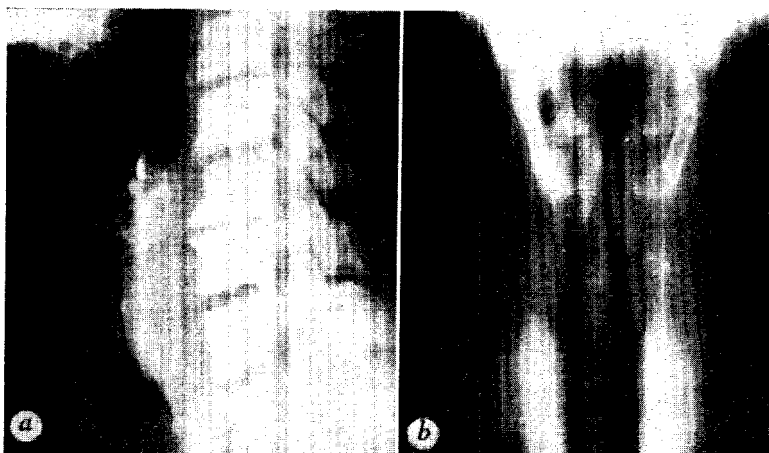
a*, Lateral roentgenogram of the larynx in case 15, demonstrating a retrotracheal soft-tissue mass causing significant narrowing of the airway: note the areas of calcification; *b*, tomogram of the larynx in the same case as in *a*, demonstrating some thickening of the true cords, and a tumor mass in the subglottic region on both sides.
